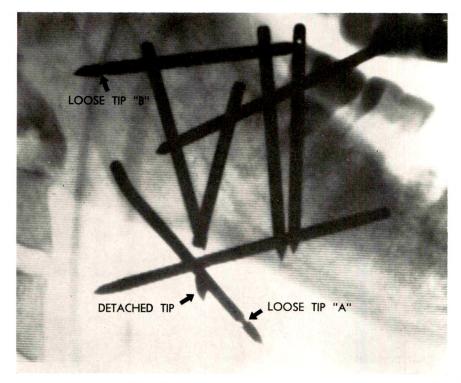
Close-up roentgenogram. Note the 2 sheath needles with loose tips (A and B). A third needle has completely lost its tip (see arrow).
